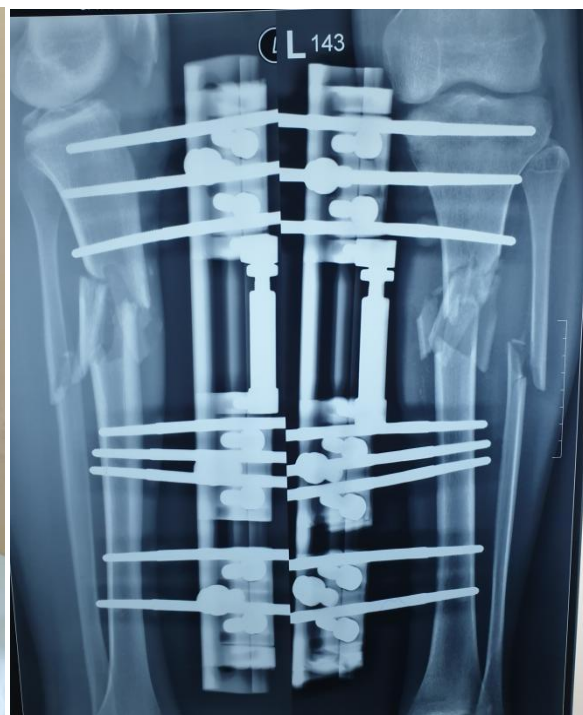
3 month post op xray
